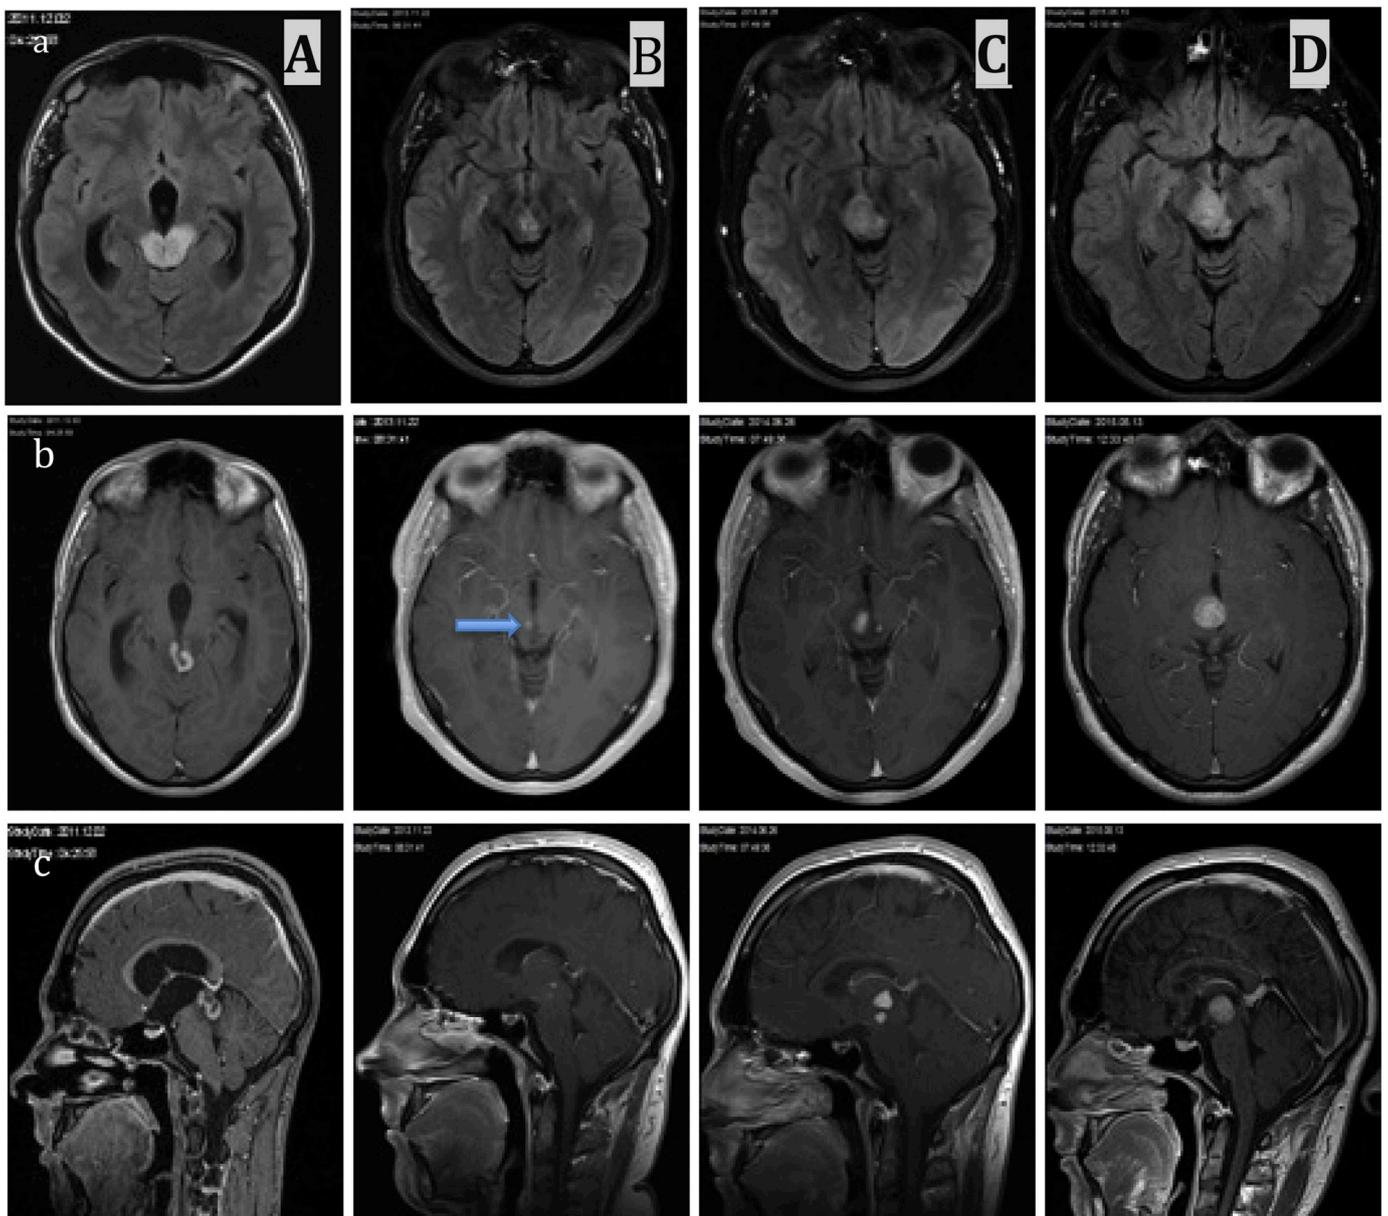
Consecutive FLAIR (a) and T1-weighted magnetic resonance images with gadolinium (b: axial plane; c: sagittal plane) showing evolution of the MRI changes over time. A. Initial MRI revealed a $1 \times 2 \times 1.5$ cm midbrain mass lesion with cystic component and homogenous gadolinium enhancement. There were also signs of occluding hydrocephalus at that time. B. The lesion almost disappeared ($> 70\%$ mass reduction) spontaneously without any treatment 2 years after initial presentation (arrow b-B). C. 7 months after regression (6/2014), marked enlargement of the midbrain mass was seen again and correlated with clinical deterioration. New gadolinium enhancing lesion in the thalamus appeared 3 years after the first clinical symptom. It was accessible for a biopsy while the original mass lesion had diminished in size again. The areas of increased T2 signal on FLAIR demonstrated only in a small circumscribed area facilitated diffusion in the ADC (data not shown).
